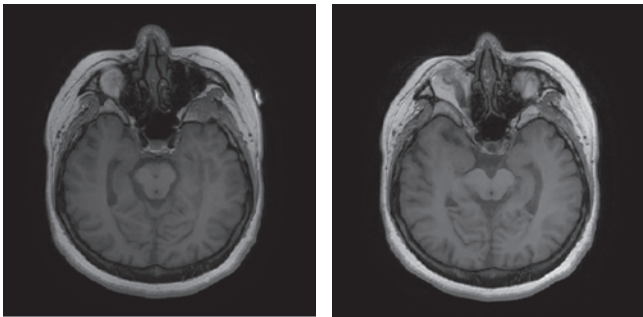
(left and right) Axial high-resolution brain MRI showing right MTS.
